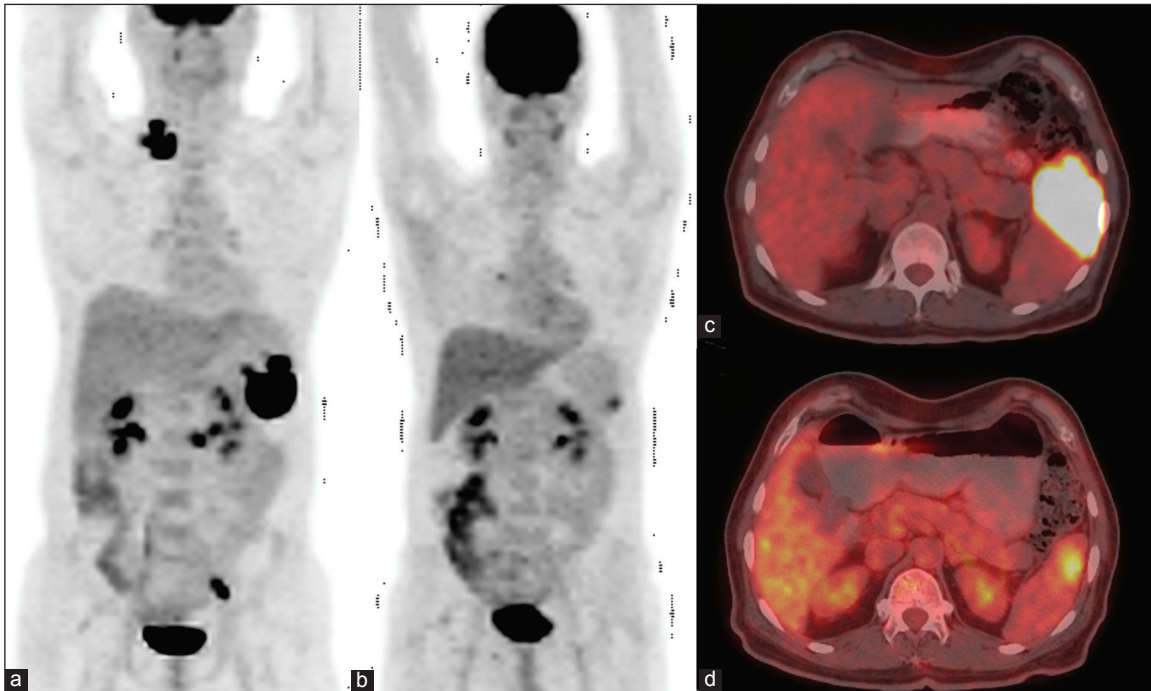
Maximum intensity projection images of pre and post therapy scans (a and b) of a patient with diffuse large B cell lymphoma (DLBCL) showing the focus of persistent fluoro-deoxy-glucose (FDG) uptake in spleen suggestive of positive positron emission tomography/computed tomography (PET/CT) indicating poor prognosis. However maximum standardized uptake value (SUV_{max}) decreased from 24.0 to 3.1 with a decrease of 82% (higher than the threshold of 66%) suggesting good response to treatment. the patient achieved a complete response (CR) after standard six cycle chemotherapy and was disease free on follow-up of 2 years. This image highlights the role of quantitative analysis in interpreting interim FDG PET/CT studies. It is well known that positive interim FDG PET/CT is highly predictive of inadequate response to chemotherapy with a higher chance for relapse and non-achievement of CR. However, visual analysis is inadequate to predict prognosis if PET/CT is done after two cycles of chemotherapy in patients with DLBCL. Less than 66% reduction in SUV_{max} from staging to interim PET/CT after two cycles has been suggested as a better poor prognostic indicator than positive scan by visual analysis^[9]
